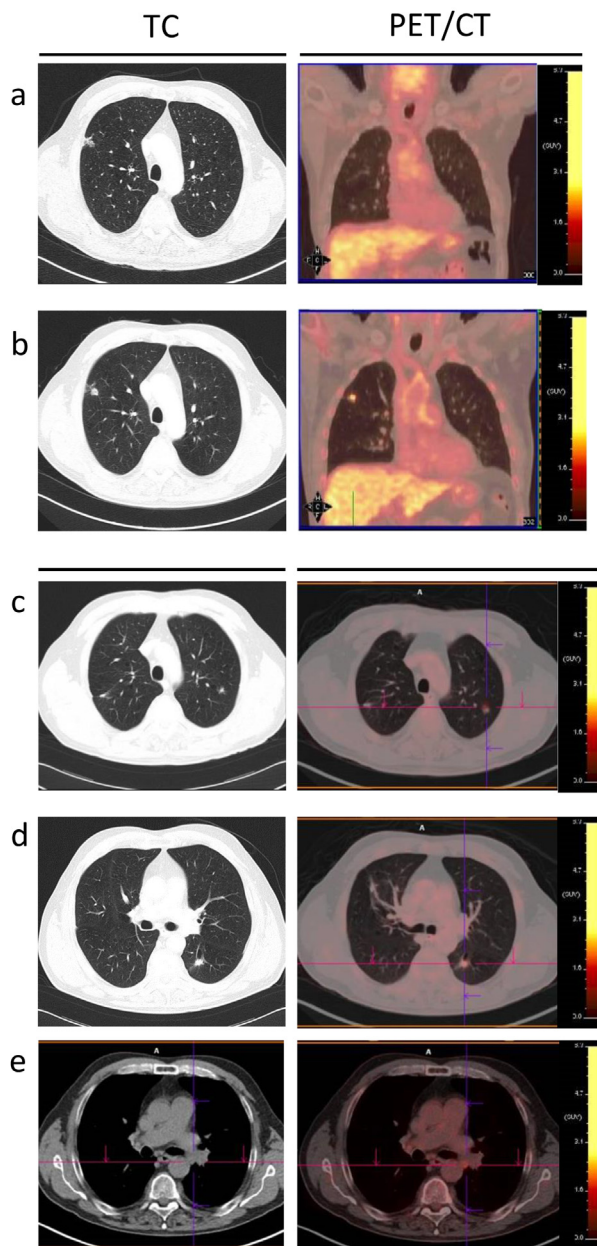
Comparative CT and PET-CT scan images of resected lung nodules. A : CT and PET-CT scans performed in April 2011 during rectal cancer staging. The suspicious non-solid tumor did not show FDG uptake; B: CT and PET-CT scans performed in February 2012 before wedge resection of the same lesion. The solid component of the nodule and its enhanced metabolic activity prompted surgical resection; C: CT and PET-CT scan images of the upper left lobe nodule. D: CT and PET-CT scan images of the lower left lobe nodule. Note its proximity to an emphysematous bulla. E: CT and PET-CT scan images showing pathologic metabolic enhancement of an ipsilateral hilar lymph node. The latter had not been detected by CT imaging.
